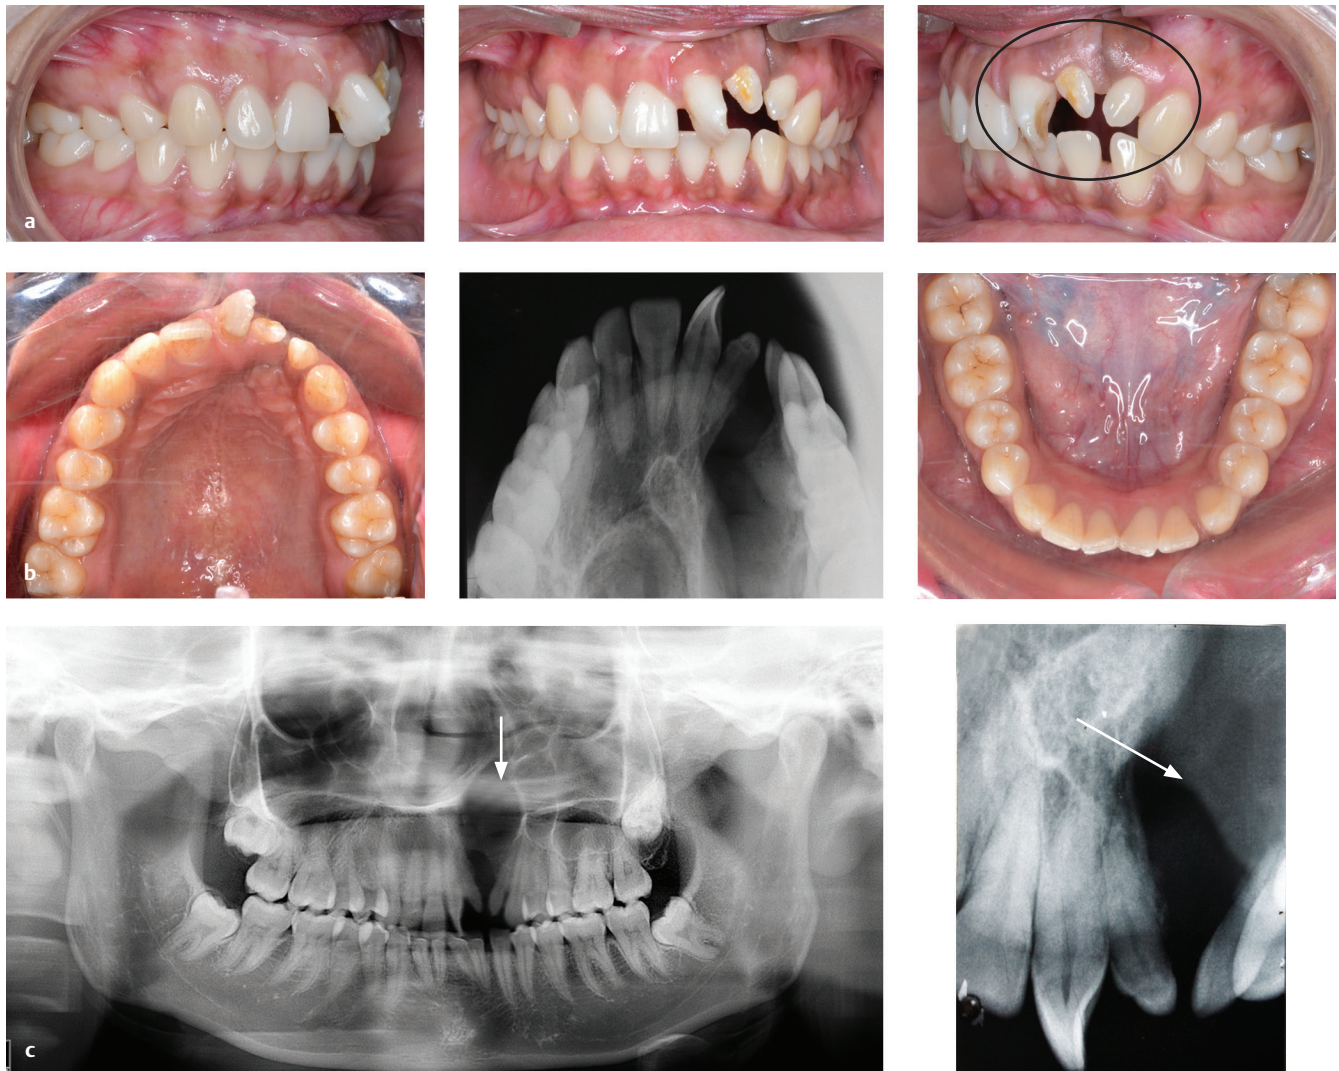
The comprehensive treatment planning should include evaluating root form and alveolar bone around the cleft region. Occlusion of an adult patient with operated cleft lip and alveolus with no history of orthodontic treatment. (a) Buccal occlusion and dental arch forms are normal, but for cleft site dental malformations (*circle*). (b) Maxillary arch shows a rotated left central incisor and rudimentary microdontic left side lateral incisor with slender root. The mandibular arch shows mild crowding. (c) Orthopantomogram (OPG) and intraoral periapical (IOPA) X-rays are showing a large bony cleft defect (*arrows*) which requires secondary alveolar bone graft (SABG).
